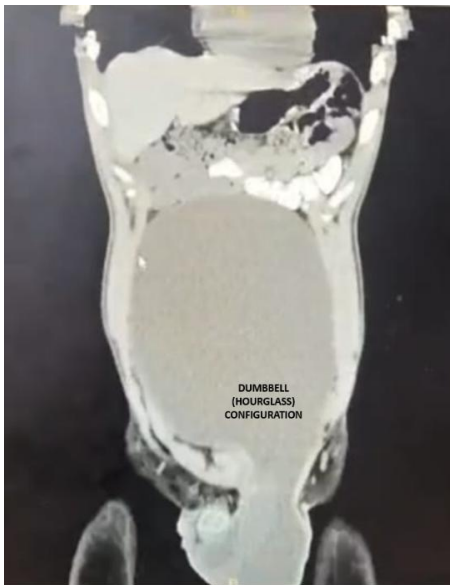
Sagittal CT scan showing giant left abdominoscrotal hydrocele extending through the inguinal canal into the abdominal cavity with characteristic dumbbell configuration.
